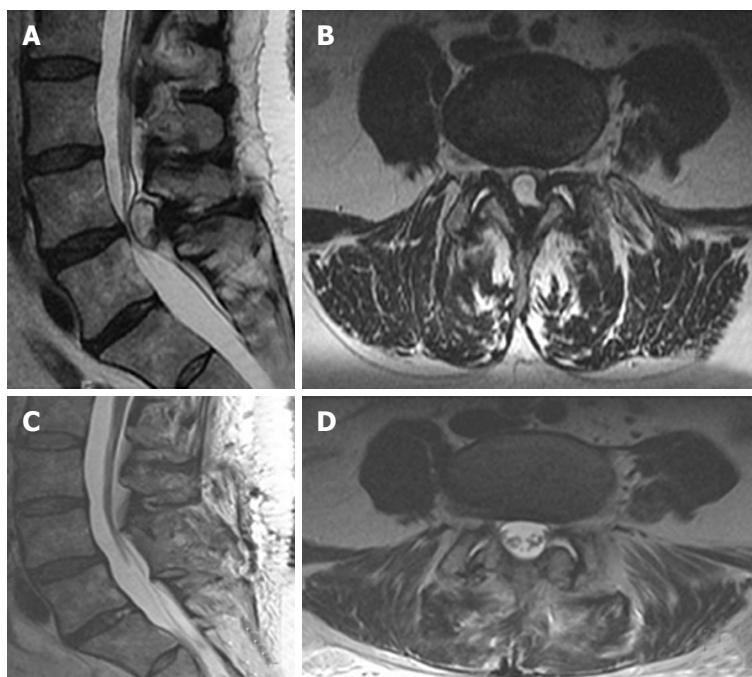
T2-weighted imaging of case 2. A, B: In the preoperative images, sagittal (A) and axial (B) T2 weighted magnetic resonance imaging displays a large intraspinal cystic lesion at the L4-5 level causing stenosis and thecal sac compression. The cystic lesion appears to have an eccentric component extending towards the left facet joint; C, D: Post-operative imaging following decompressive laminectomy and cyst excision. Bilateral laminectomies at L4-5 and cyst resection provide adequate decompression of the dorsal thecal sac and cauda equina, as shown in sagittal (C) and axial (D) images.
